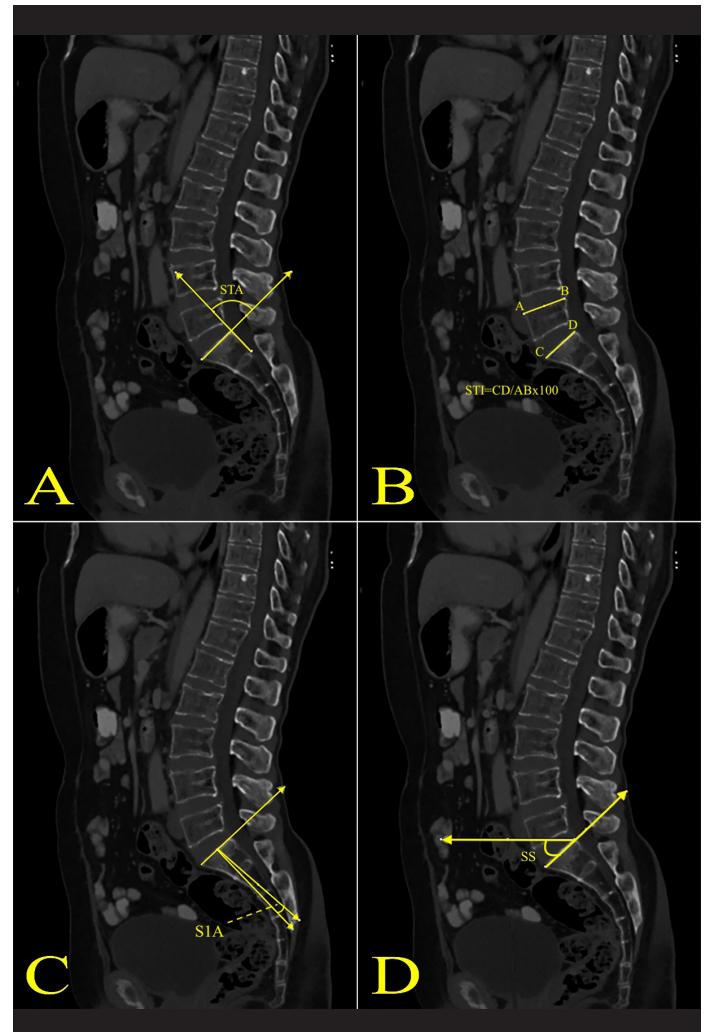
A. STA measurement on sagittal CT, B. STI measurement on sagittal CT, C. S1A angle on sagittal CT, D. SS angle measurement on sagittal CT
